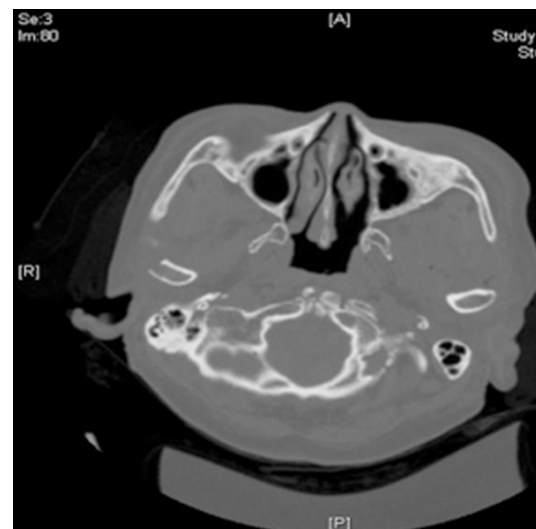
Postoperative CT examination showing no recurrence.
